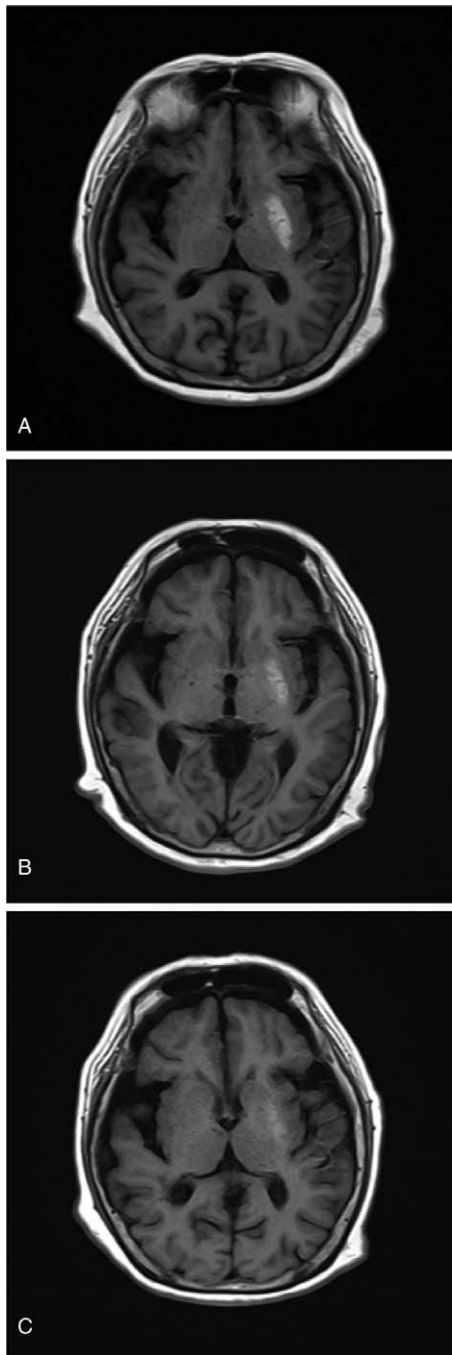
Signal changes in DS shown on brain MRI images (T1 FLAIR) taken (A) 40 days, (B) 3.5 and (C) 6.7 months after the initial hemichorea-hemiballism event. Fainter DS signals in the left basal ganglion were visualized in this series of images.
